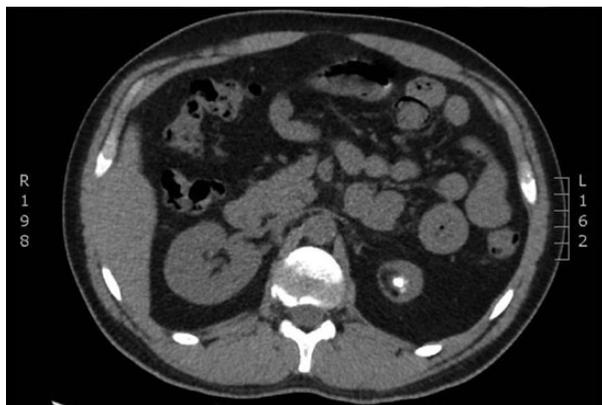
CT scan of index case shows large calculus in the left kidney with marked atrophy.
